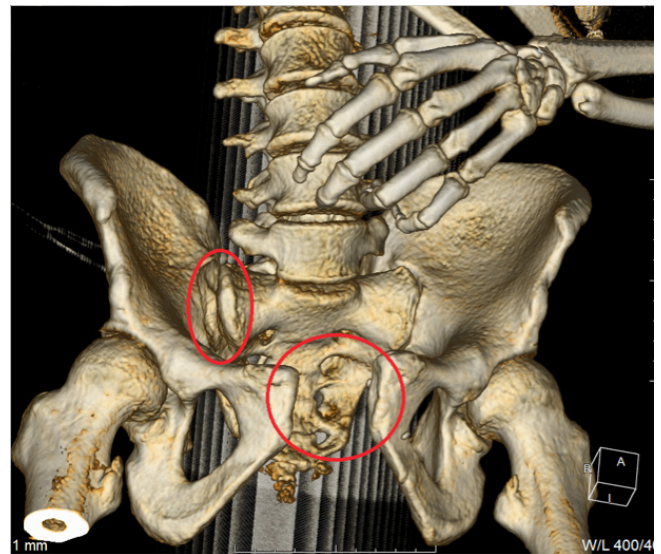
3D CT model of the pelvic ring injury: red ovals show the right sacroiliac joint rupture and the pubic symphysis rupture
